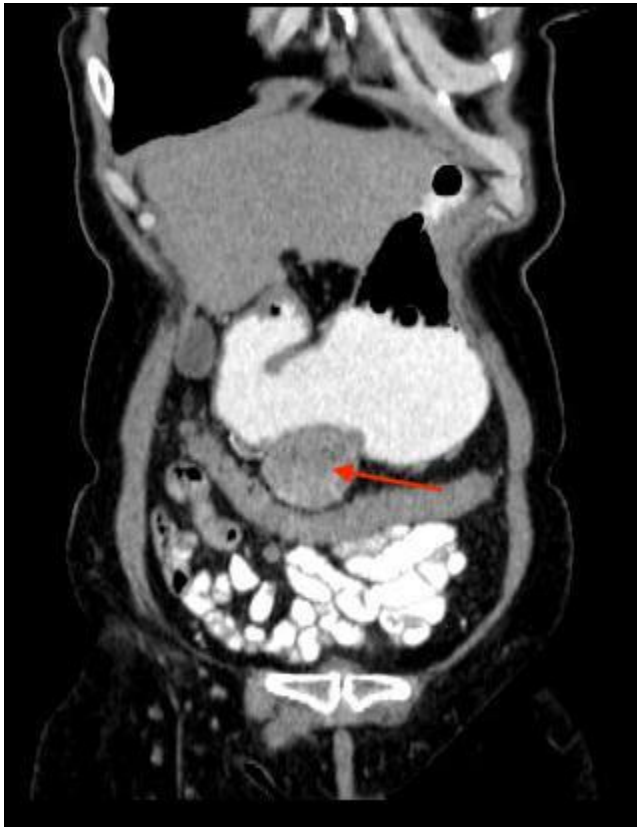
A: Coronal CT image of the mass (Red arrow).
